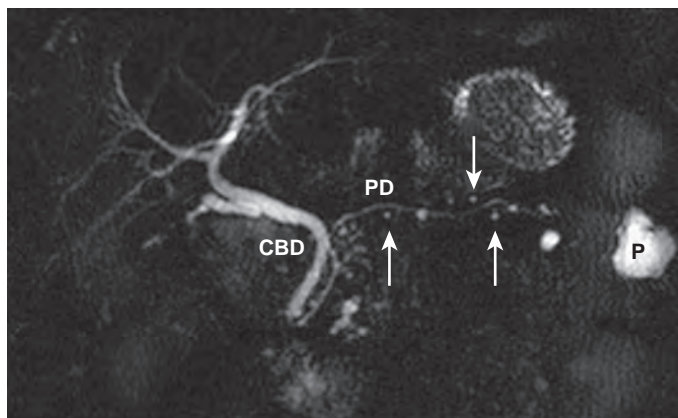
Early chronic pancreatitis. Coronal T2-weighted thick-slab RARE MR image shows mild dilation of the secondary branches of the pancreatic duct (arrows) and pseudocyst (P) in the pancreatic tail. The main pancreatic duct (PD) and the common bile duct (CBD) have normal caliber. (From Miller FH, Keppke AL, Wadhwa A, et al: MRI of pancreatitis and its complications: Part 2, chronic pancreatitis. *AJR Am J Roentgenol* 183:1645–1652, 2004. Reprinted with permission from the American Journal of Roentgenology.)
